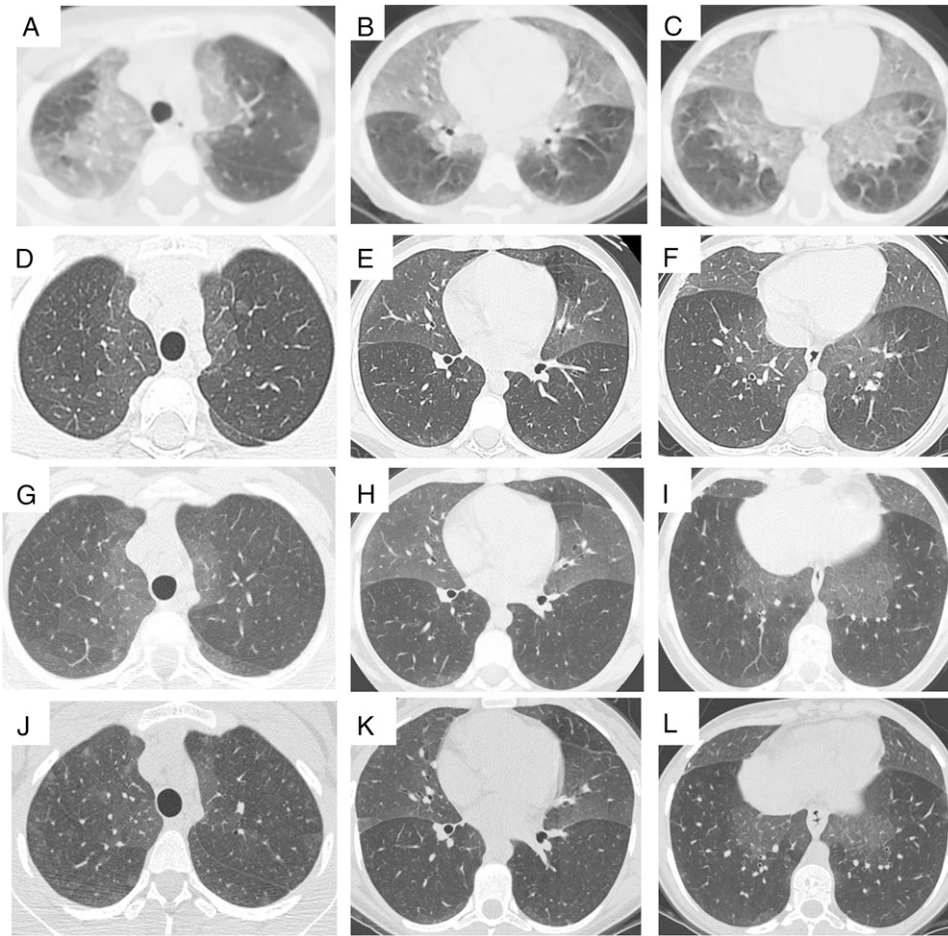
A-L, Serial chest CT scans from the proband with NEHI. Serial chest CT scans (A-C, age 3 y; D-F, 8 y; G-I, 12 y; and J-L, 17 y) show persistence of characteristic geographic ground-glass opacities centrally and most prominently in the right middle lobe and lingula, highly consistent with NEHI. No architectural distortion or other abnormalities are present. See Figure 1 legend for expansion of abbreviation.
